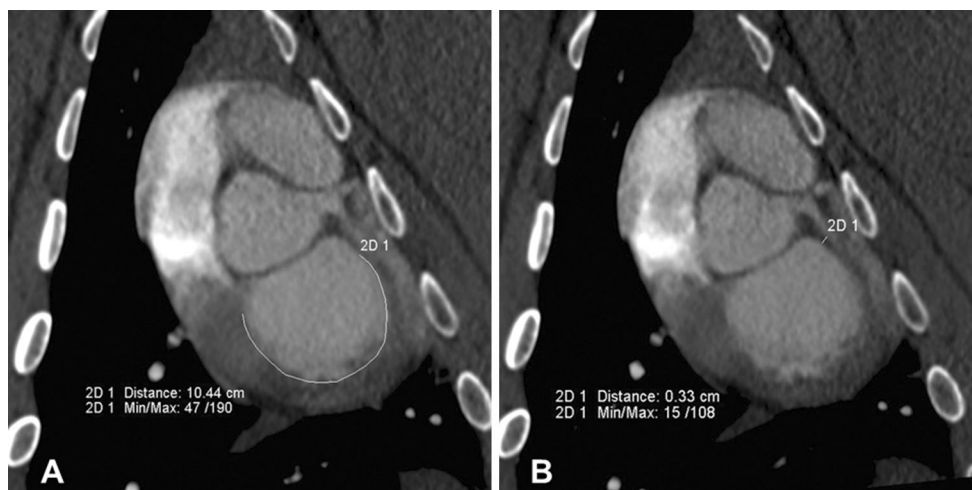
CT short-axis reformations parallel to the mitral annulus showing the measurements of the a posterior mitral annular circumference and the b shortest distance of the posterior mitral annulus to the circumflex artery
